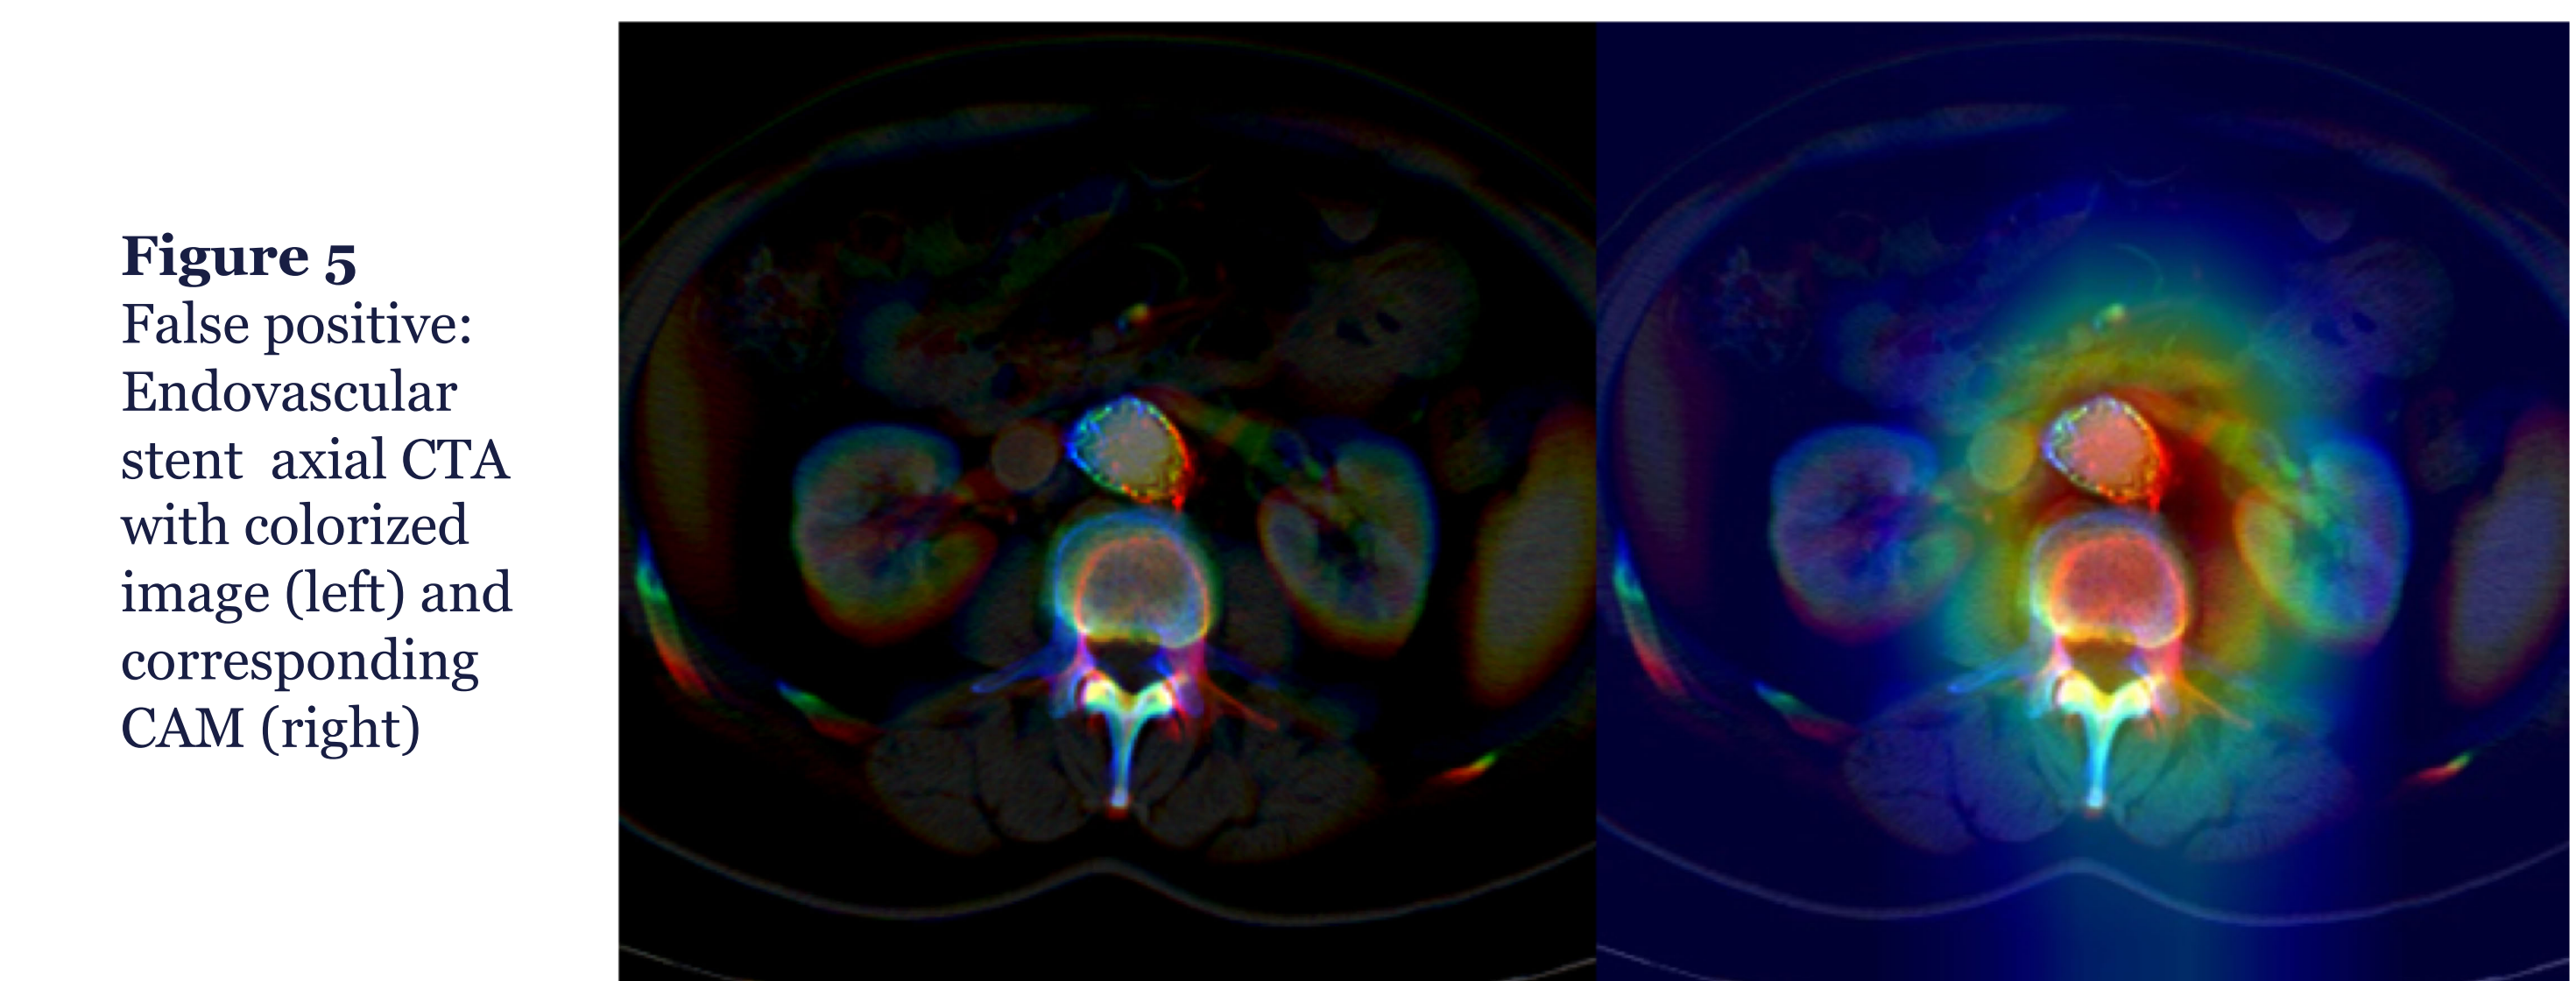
False positive: Endovascular stent axial CTA with colored image (left) and corresponding CAM (right)
